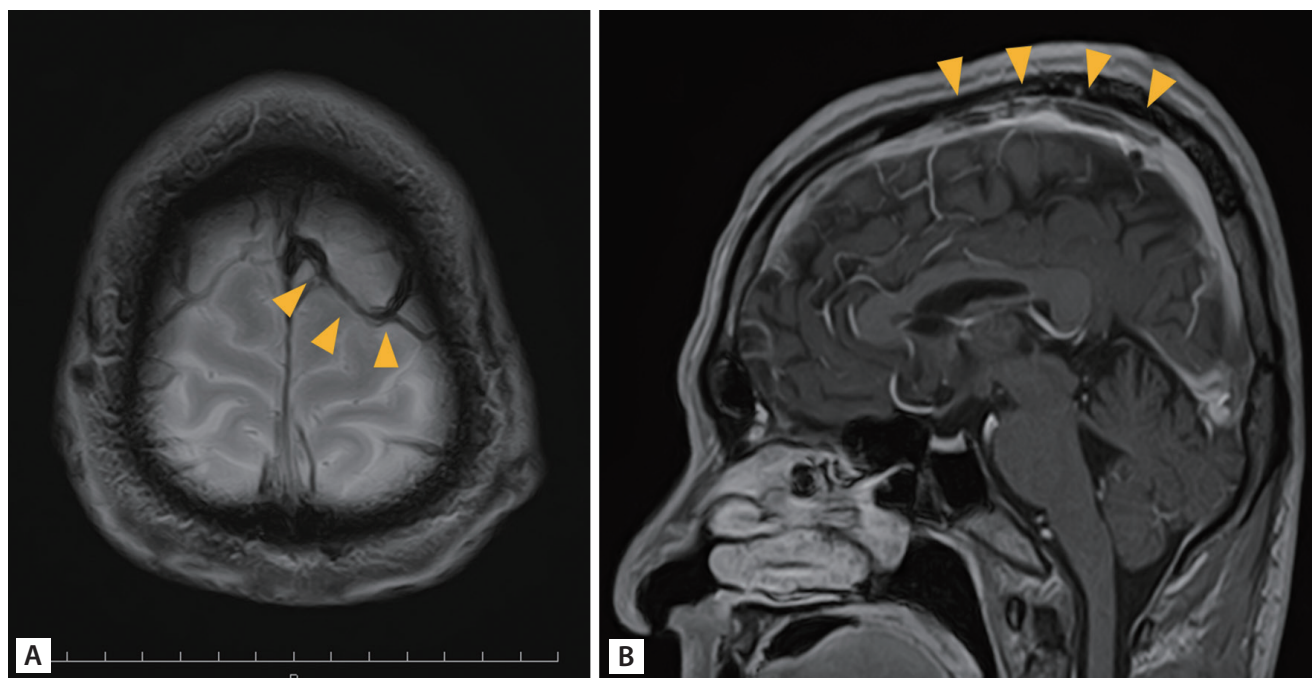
On T2*-weighted magnetic resonance imaging, (A) a linear no-signal along the blood vessel (arrowheads) is observed in the left frontal cortex, and (B) a signal defect (arrowheads) is found in the superior sagittal sinus.
